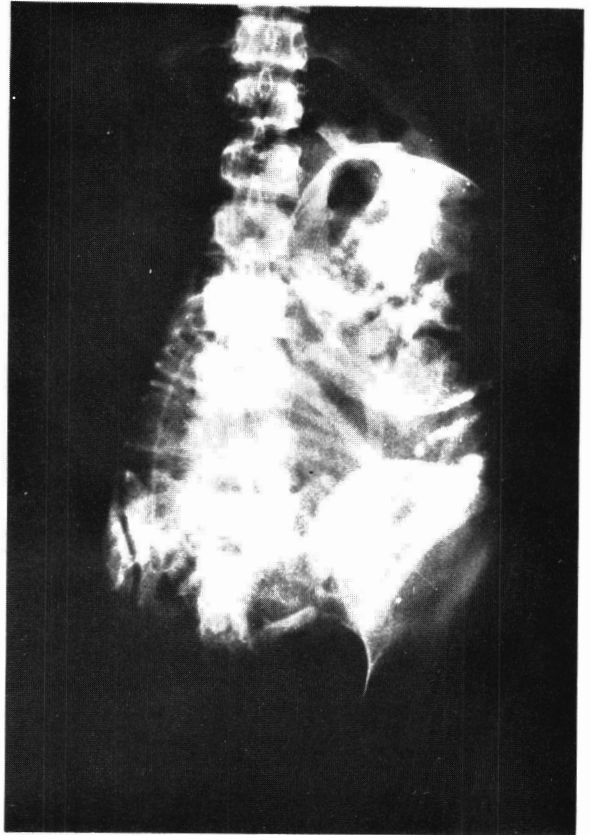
X-ray of the abdomen — antero-posterior view showing the classical signs of intra-uterine foetal death.
